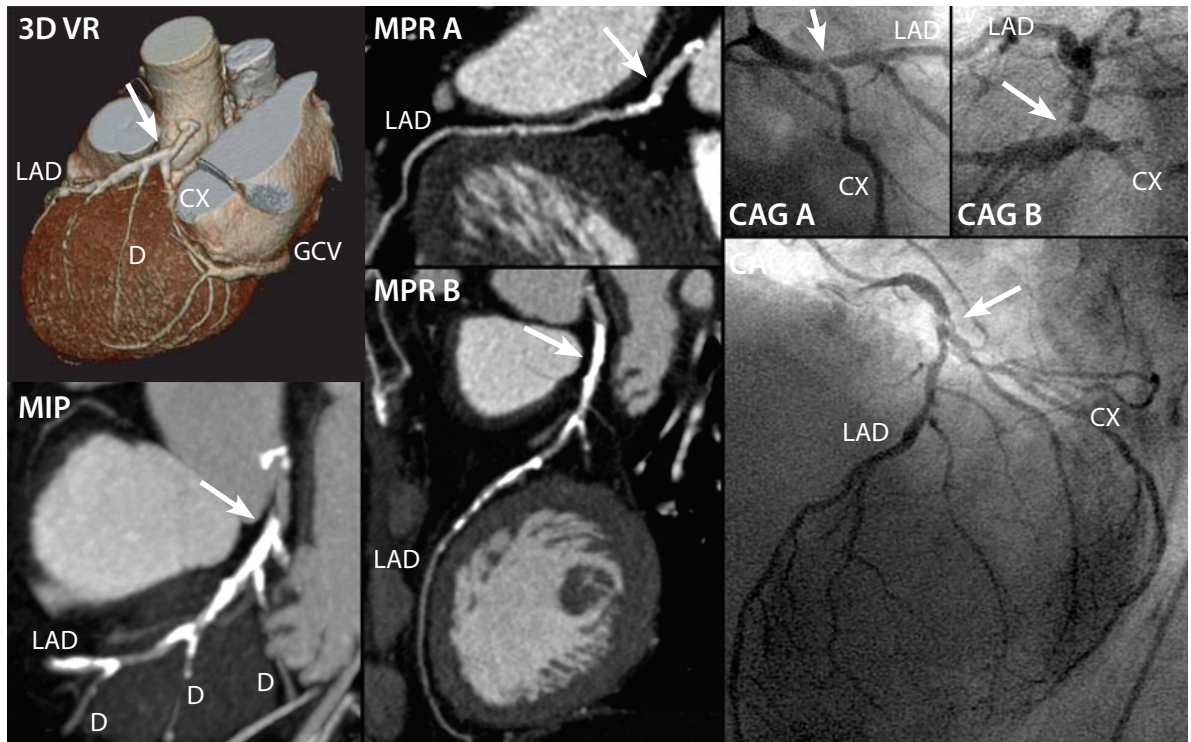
A missed lesion due to coronary calcification, examined with 16-slice CT. The lesion (*arrow*) at the ostium of the LAD, according to CAG, was missed by multi-slice CT using different post-processing techniques: curved MPR, MIP, and 3D VRT. The reason is extensive coronary wall calcification
